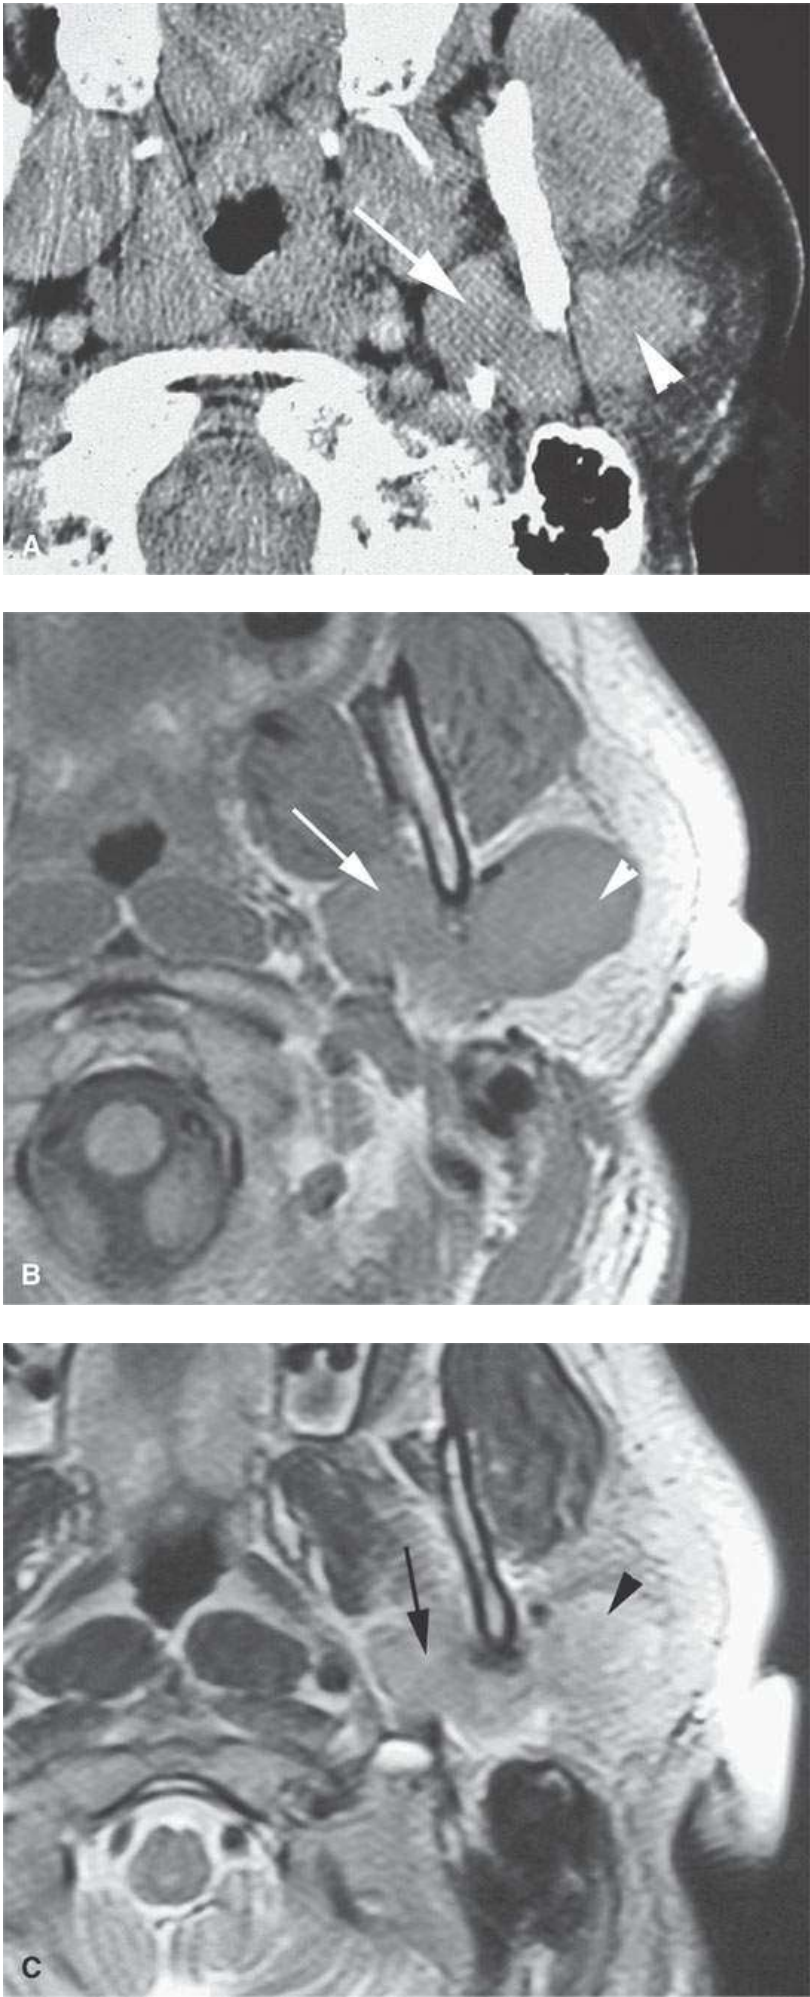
Computed tomography and magnetic resonance imaging study in a patient with an oncocytoma both deep (arrows) and superficial (arrowheads) to the plane of the main trunk of the facial nerve: contrast-enhanced computed tomography (A), contrast-enhanced T1-weighted image (B), and T2-weighted image (C).
